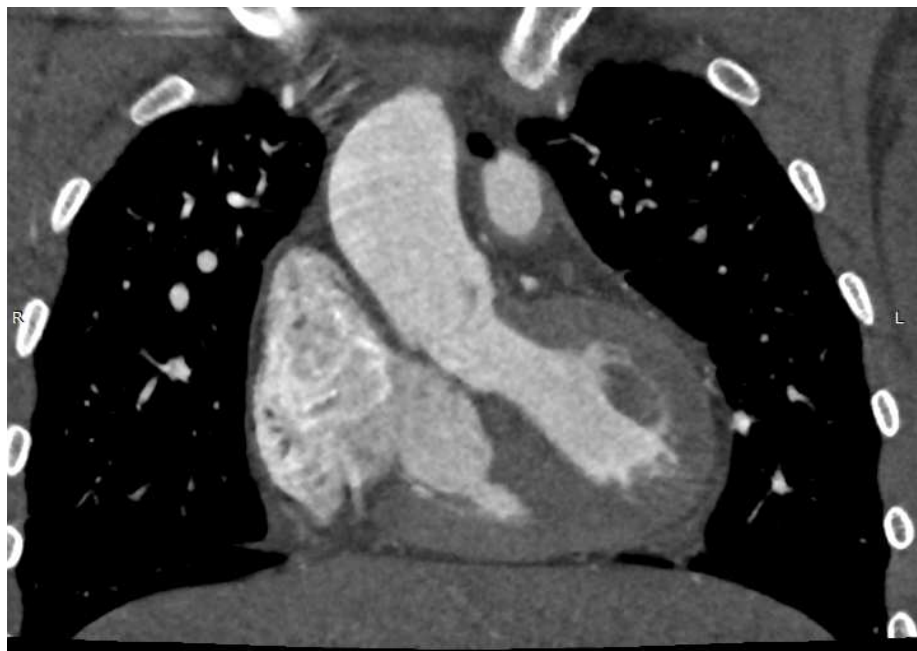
Coronal view of a CT scan during the acquisition process.*
